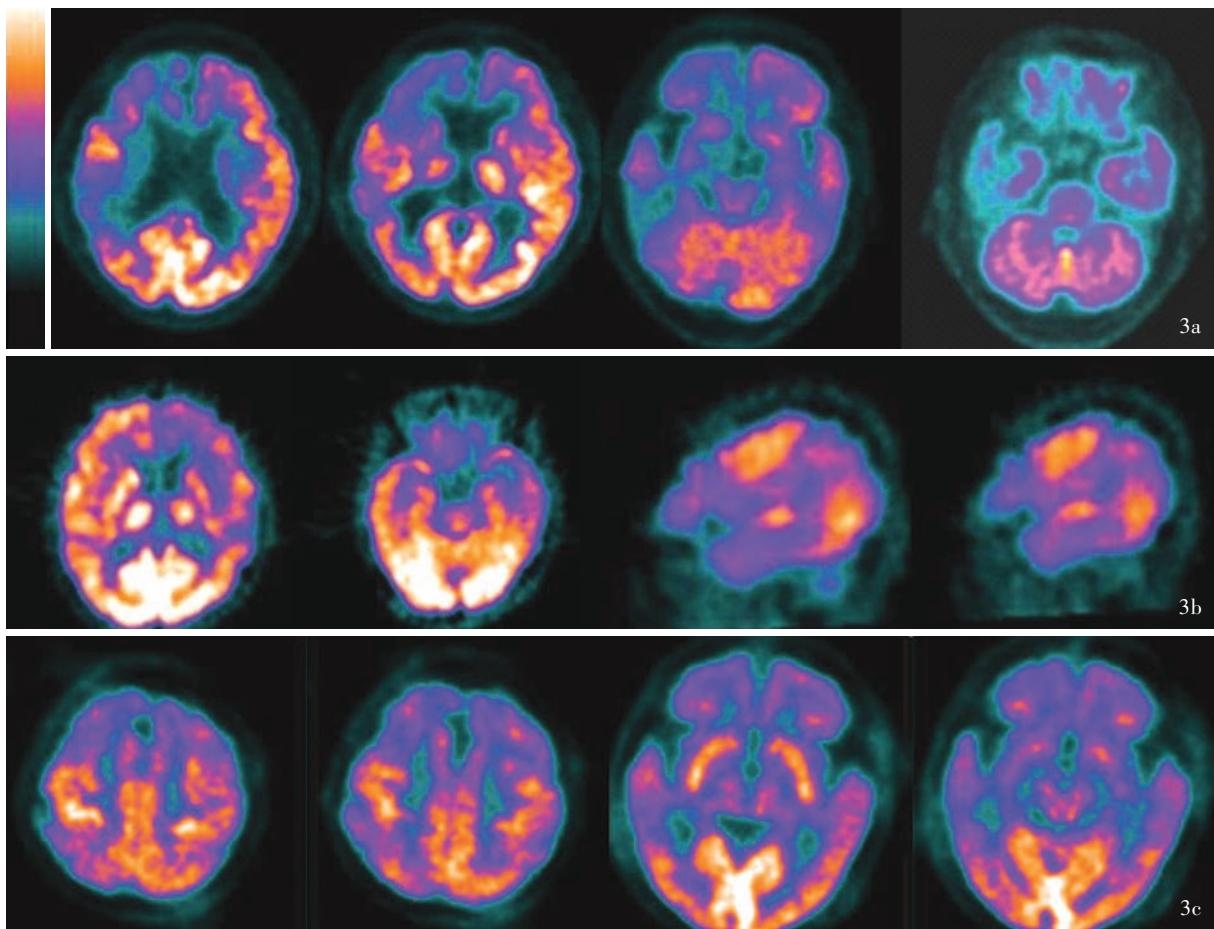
额颞叶痴呆患者皮质代谢降低的3种模式 3a 女性患者,72岁。临床表现为明显行为异常,尤以脱抑制表现最为突出。连续横断面¹⁸F-FDG PET显像,右侧额颞叶皮质代谢明显降低(蓝紫色区域所示),同时伴同侧基底节、丘脑代谢降低 3b 女性患者,57岁。表现为行为举止怪异且伴命名、找词困难等语言障碍。连续横断面¹⁸F-FDG PET显像,左侧额颞叶皮质代谢明显降低(蓝紫色区域所示);矢状位显像,左侧额叶和顶叶部分皮质代谢降低(蓝紫色区域所示);同侧基底节、丘脑代谢降低 3c 男性患者,62岁。主要表现为行为异常、执行能力减退、记忆力下降。连续横断面¹⁸F-FDG PET显像,双侧额叶和前颞叶皮质呈基本对称性代谢降低(蓝紫色区域所示)
